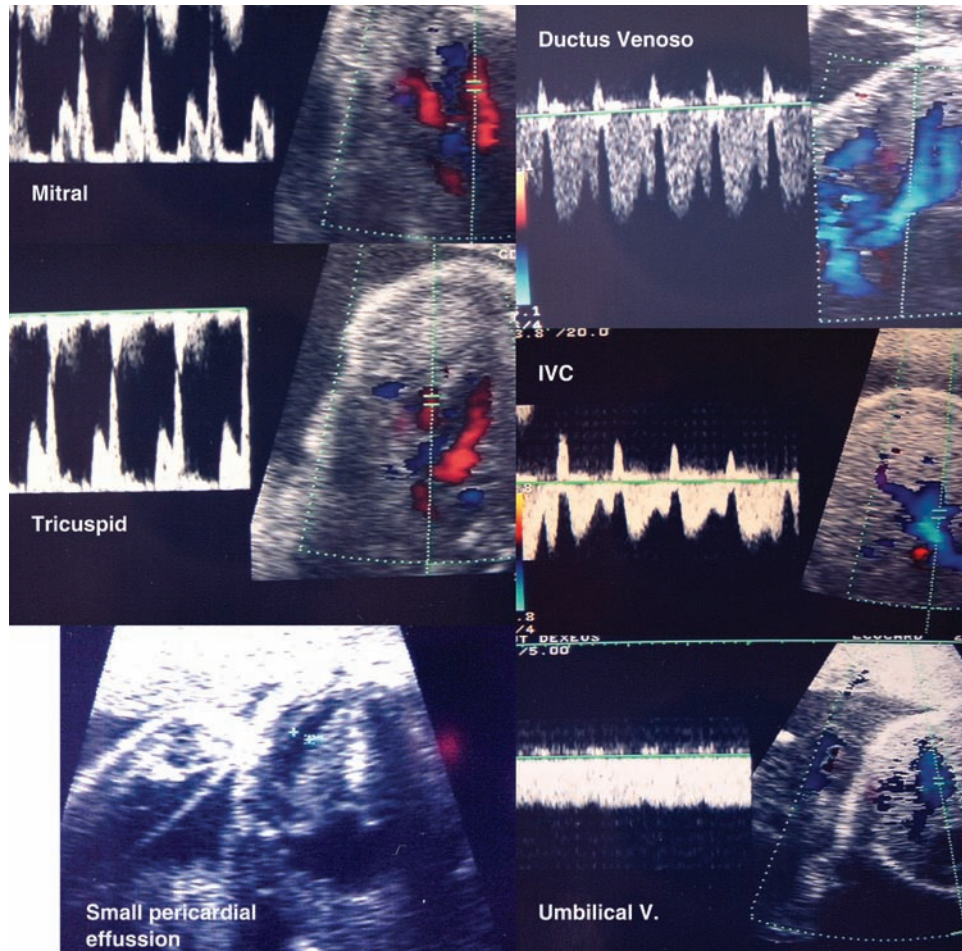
A number of Doppler signs can predict fetal heart failure: increased 'a' in A-V flow; deep diastolic phase at ductus venosus flow; prominent and negative 'a' wave at the inferior vena cava; small pericardial effusion; pulsatile deflection at the umbilical flow.
